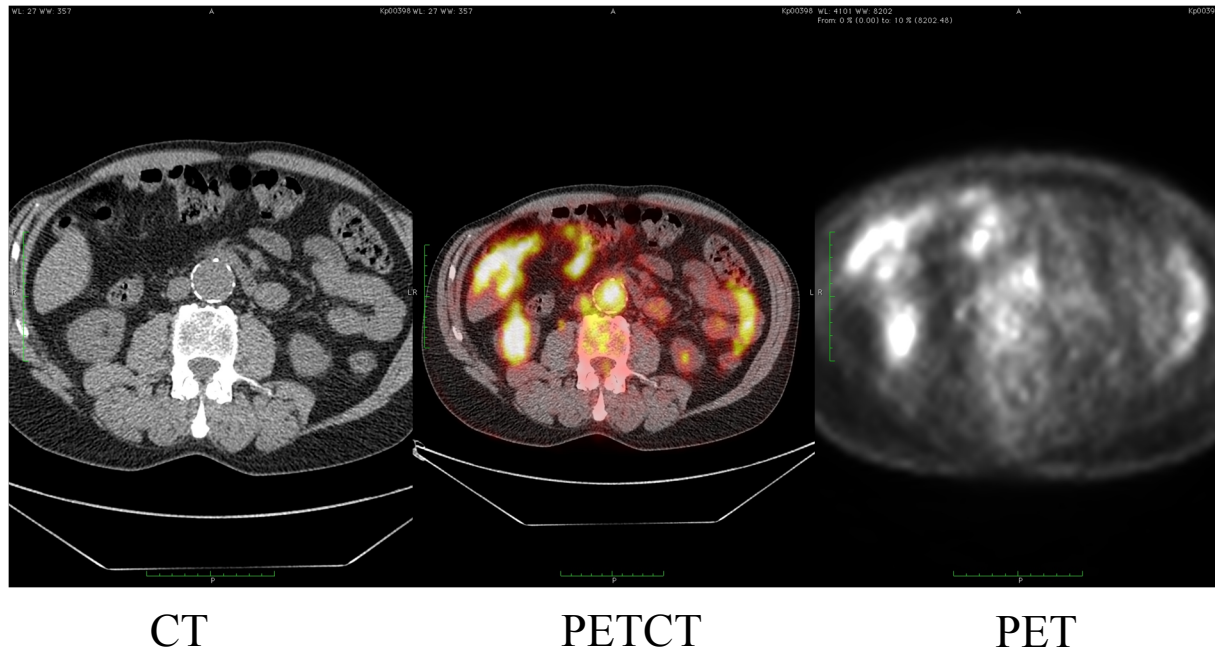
Positron emission tomography-computed tomography (PETCT) scan of a AAA patient.
